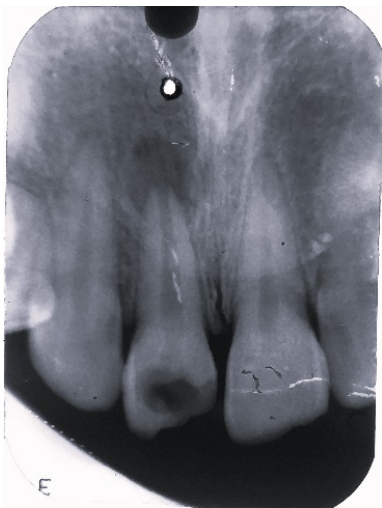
Pre-operative radiograph showing open apex with a periapical lesion with respect to 21.
